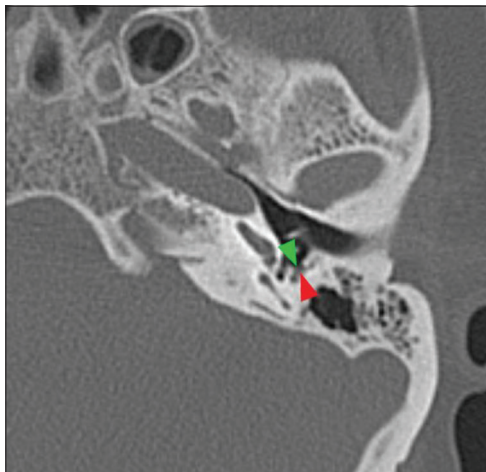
Anterior dehiscence in the proximal part of the mastoid segment of the facial canal on temporal computed tomography taken in the axial plane (red arrowhead: facial canal, green arrowhead: dehiscence)
